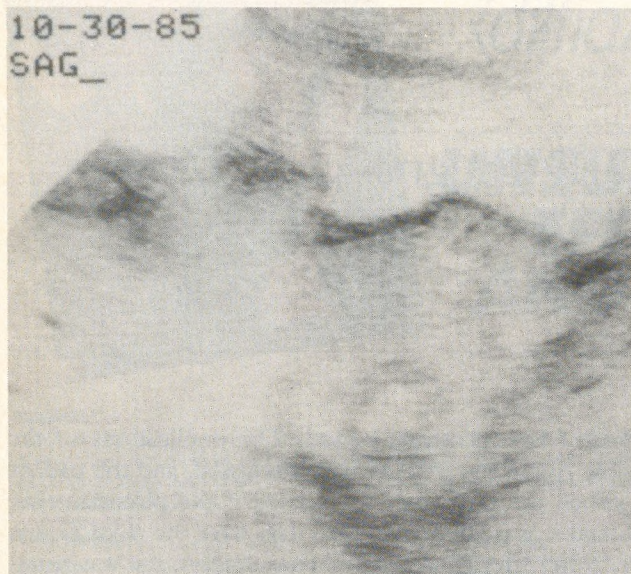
Pelvic ultrasonogram 7 weeks after last menstrual period (case 1). Note the echogenic ring in the uterus without a fetal pole, consistent with a blighted ovum.
